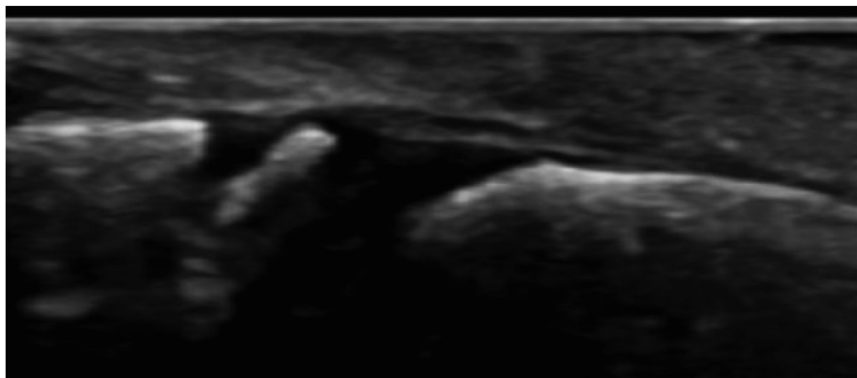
Ultrasound image of the dorsal aspect of the right middle finger's distal interphalangeal joint in a healthy 8-y-old child.
